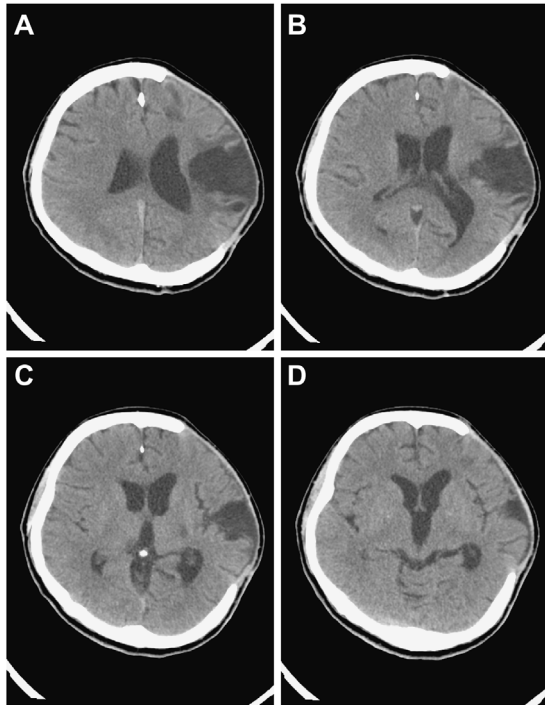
Follow-up brain CT (computed tomography angiography) on November 26, 2021, (A-D) reveals the resolution of the paradoxical hernia. Postoperative changes with bone defects and old cerebrovascular accidents with low-density changes were also noted in the right frontotemporoparietal area
